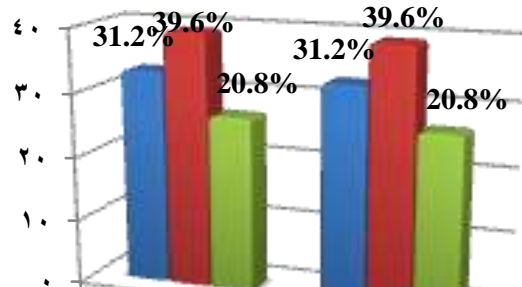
Comparison of CT versus the MRU regarding the level of ureteric obstruction.
